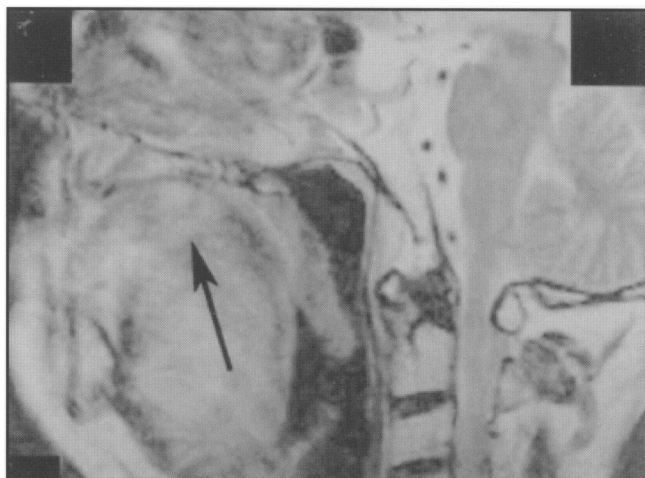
Sagittal T2-weighted MR image demonstrates a hyperintense mass (*arrow*).
